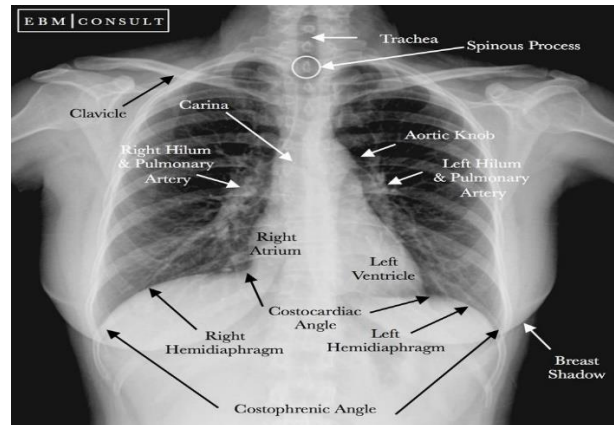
CHEST X-RAY<sup>18</sup>.
